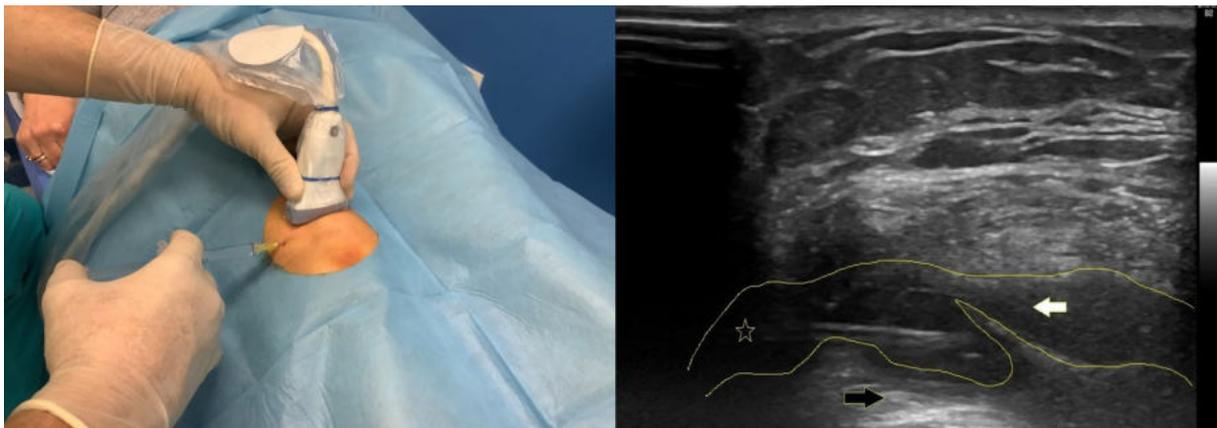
VSAP based injection of a knee joint. Right – ultrasound view, needle - asterix, arrow white - joint cavity infiltrated with HA, arrow black supracondylar fat pad.
